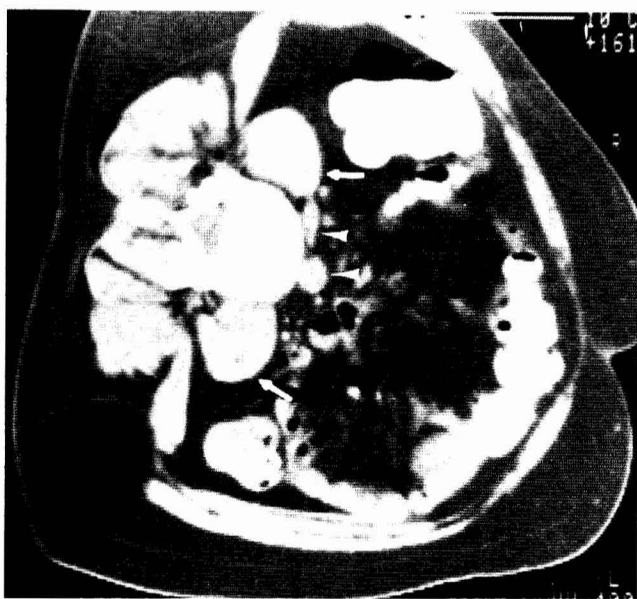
Abdominal CT scan, at the level of the L-4, L-5 interspace, obtained after the oral administration of contrast medium with the patient in the surgical position for a right-sided approach to the intervertebral disc. Neither the major vessels (*arrowheads*) nor segments of bowel present an obstruction to the retroperitoneal surgical path on the right side. The psoas muscles are indicated by the *arrows*.
